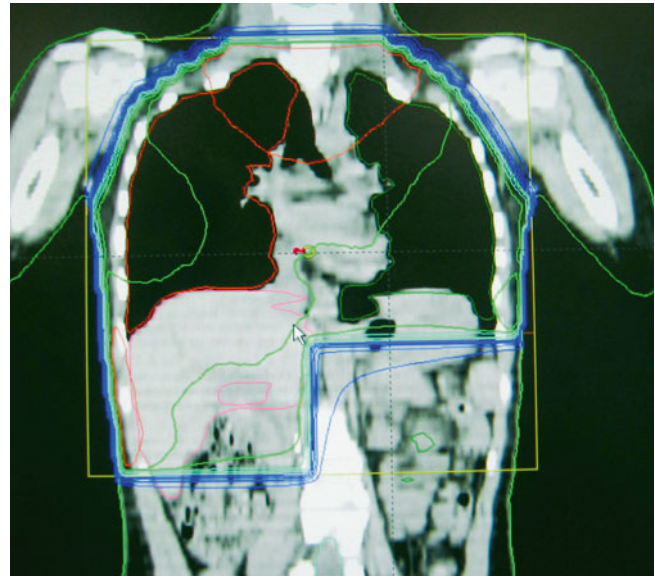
Sagittal reformatted planning CT scan showing fields for a patient with Wilms tumour requiring radiotherapy to both lungs and right flank
